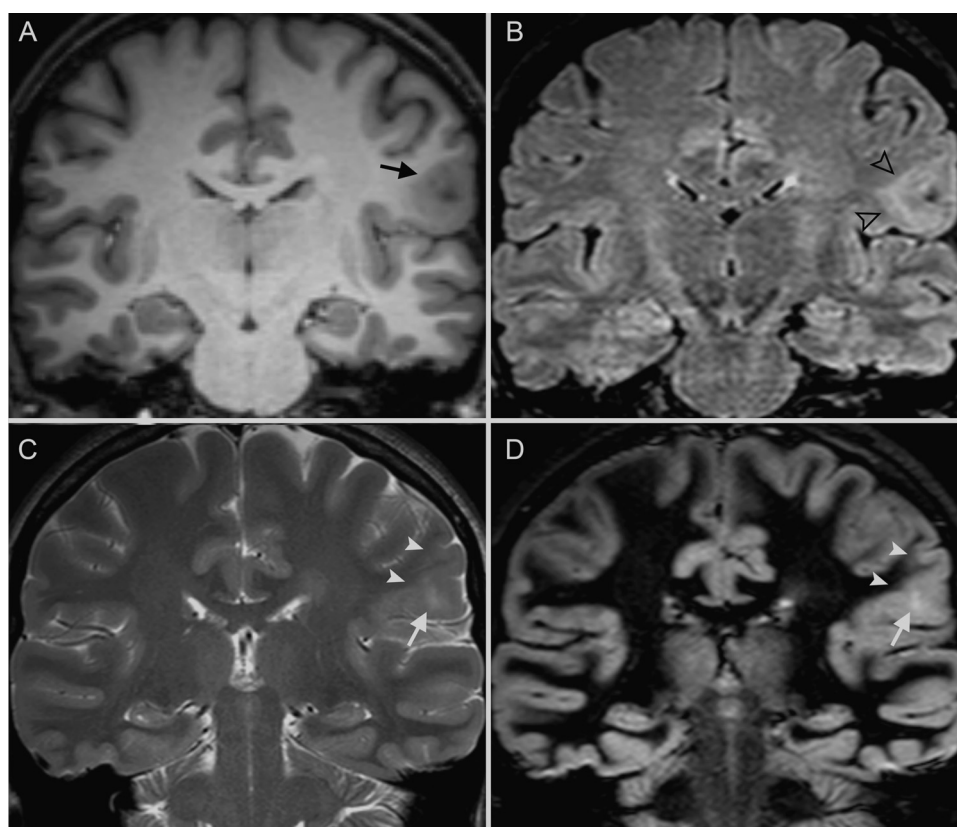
Left parietal Focal Cortical Dysplasia (FCD). Coronal T1-weighted image (A) shows the increased cortical thickness (black arrow). Coronal FLAIR image (B) shows the white matter hyperintensity (empty black arrowhead). Coronal T2 (C) and coronal DIR (D) images show white/gray matter blurring (white arrowhead) and increased cortical signal (white arrows).
